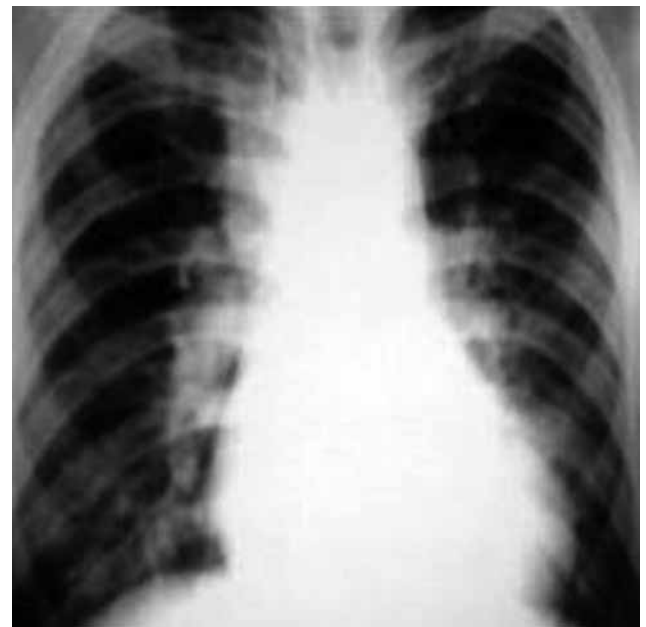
Preoperative chest radiograph of a patient showing the increased cardiothoracic ratio and pulmonary plethora.
